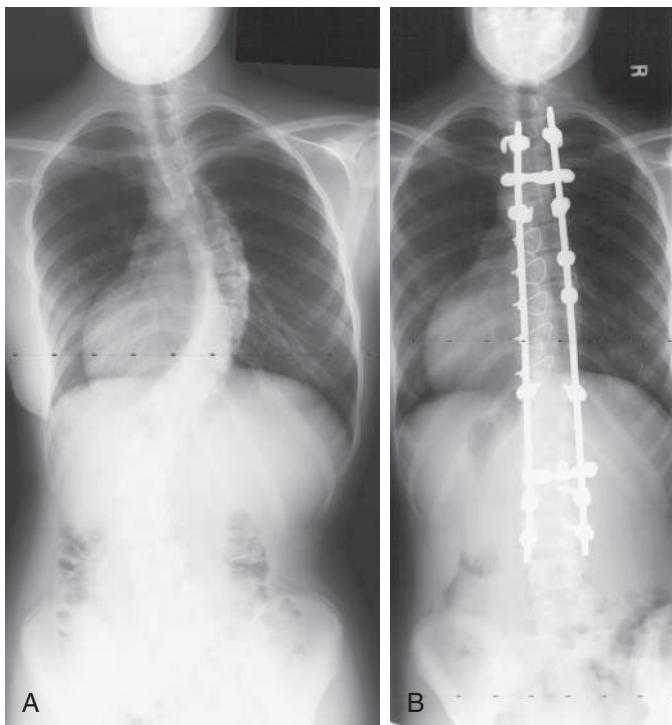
Preoperative standing posteroanterior radiograph of a 14-yr-old female who was skeletally immature and developed a 68-degree right thoracic and a 53-degree left lumbar scoliosis (A). Her trunk was shifted to the right, and the left shoulder was slightly depressed. Based on the risk of future progression, she was treated by an instrumented posterior spinal fusion from T3 to L3 with correction of the right thoracic curve to 20 degrees and the left lumbar curve to 10 degrees (B). Coronal spinal balance was restored, and shoulder height was maintained.
